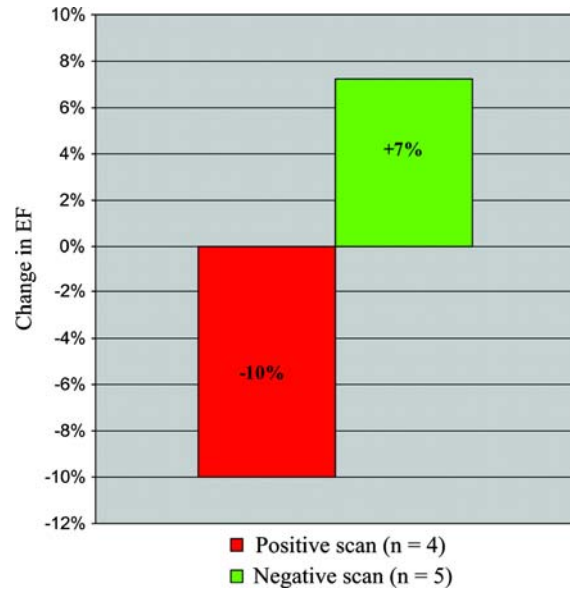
Differences in left ventricular ejection fraction after 1 year follow-up in CDMF patients with uptake of Annexin A5 and no uptake of Annexin A5 on SPECT (adapted from Kietselaer et al³⁰).
